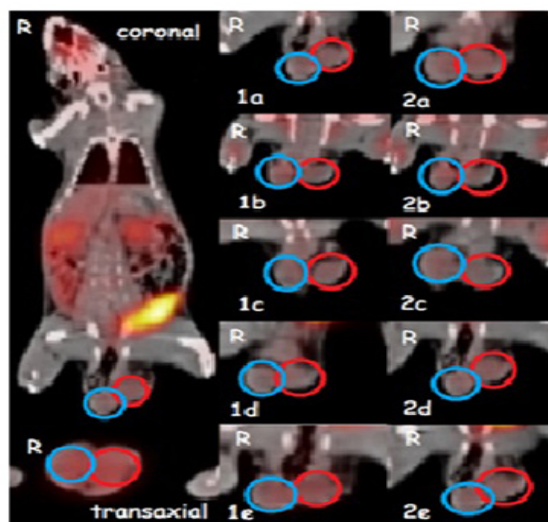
Examination of glucose metabolism using PET/CT with ¹⁸F-FDG; one day sham control (1a), torsion (1b), melatonin (1c), PMF (1d), melatonin plus PMF (1e), and one week sham control (2a), torsion (2b), melatonin (2c), PMF (2d), melatonin plus PMF (2e).
